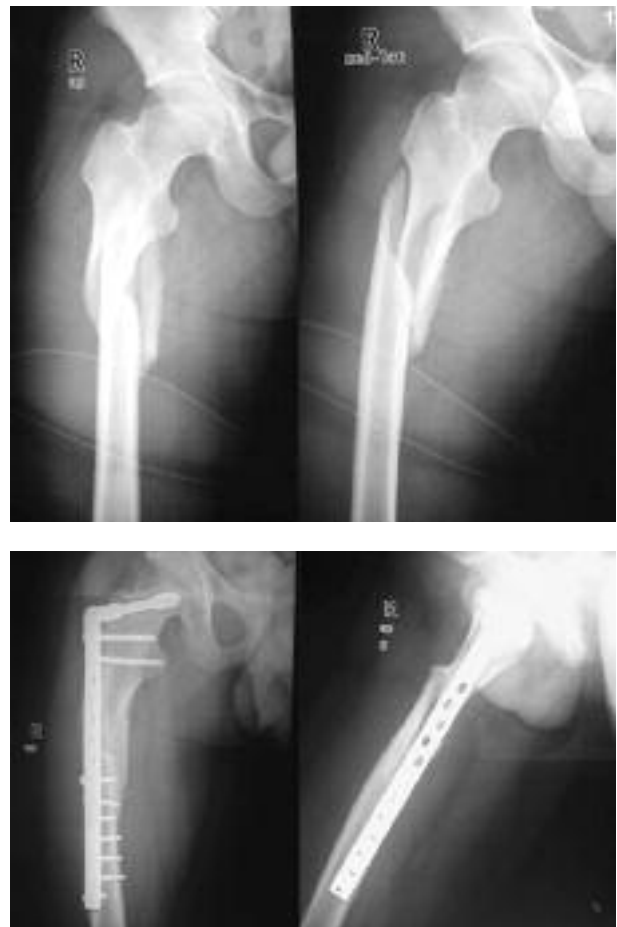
Case 1. a : Pre-operative radiograph ; b : Radiograph showing fracture union with good callus formation.
